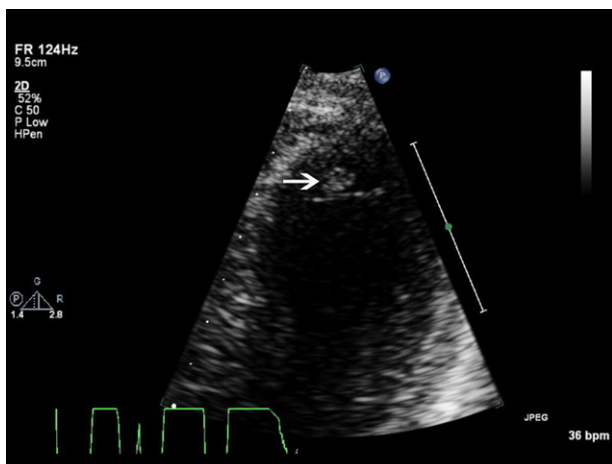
Echocardiogram with thrombus in the apex of the left ventricle.
